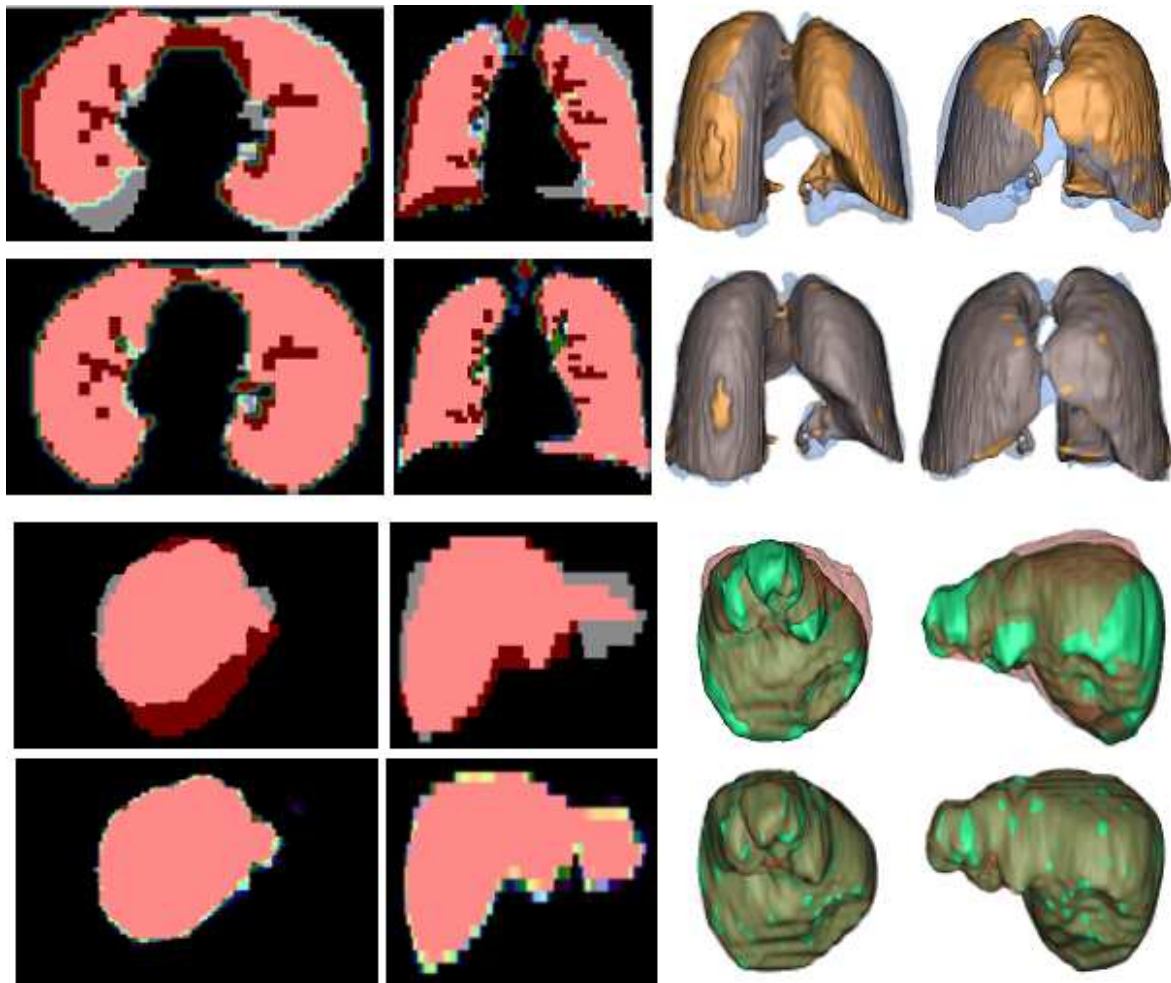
Structure registration results obtained with the RMS-FFD method. Left part of the figure: 2D coronal and axial slices of CT (grey) segmented lungs (top rows) and liver (bottom rows) are superimposed on their homologous PET structures (red), registered with a linear transformation (first and third row) and with the RMS-FFD method (second and fourth row). Right part of the figure: a 3D representation of the same structures is shown (CT lungs in blue, registered PET lungs in brown, CT liver in green and registered PET liver in red).
